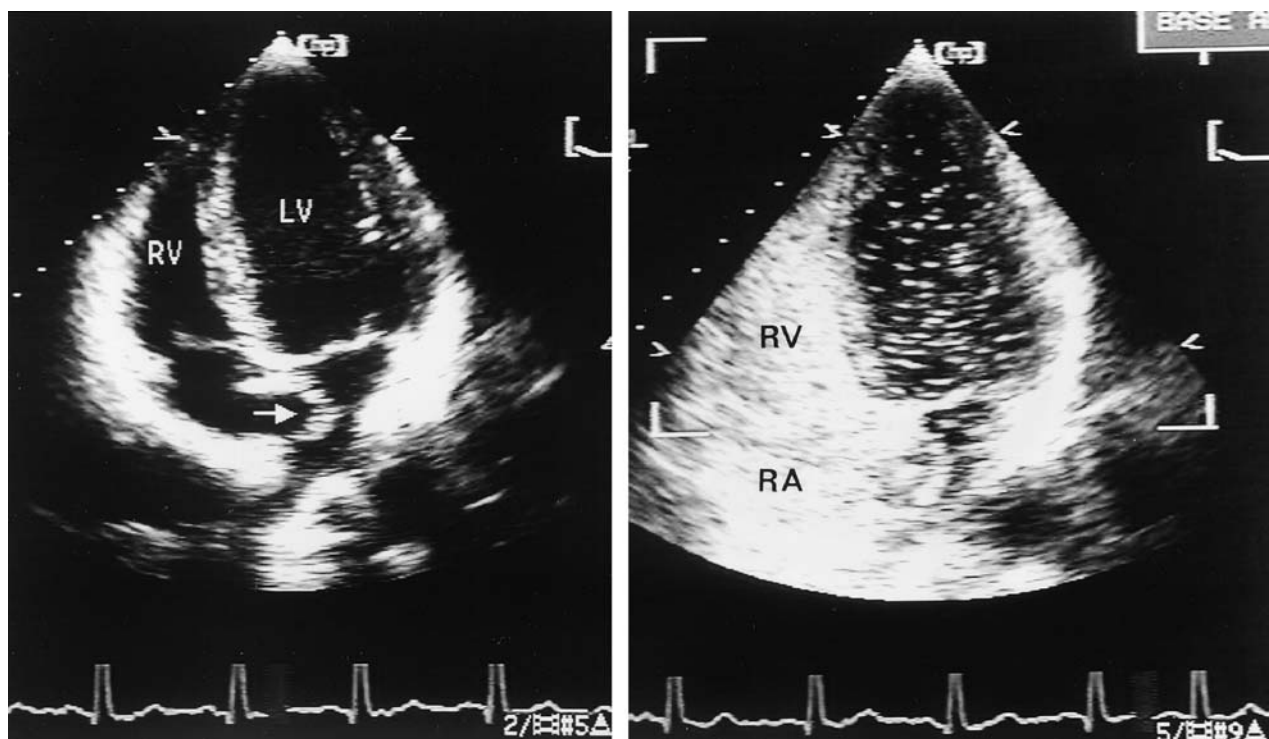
Apical four-chamber view recorded in a patient with an atrial septal aneurysm. Note the marked bulging of the atrial septum into the cavity of the left atrium (arrow). The right-hand panel is recorded after injection of saline contrast medium. Note the contrast medium has filled the right ventricular cavity, and there are numerous individual microbubbles seen in the cavity of both the left atrium and left ventricle, consistent with a right-to-left shunt through fenestrations in the atrial septal aneurysm.
